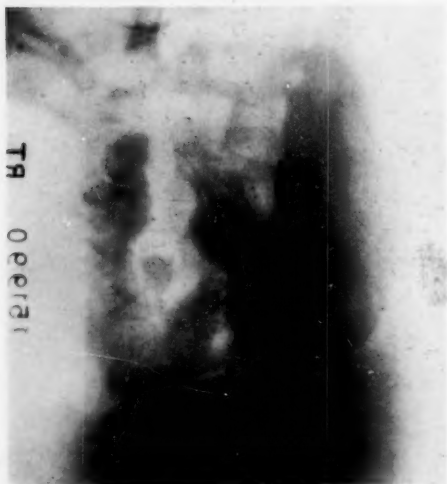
Ten-minute gastric roentgenogram. Note the duodenal diverticulum showing between the pylorus and duodenum.
